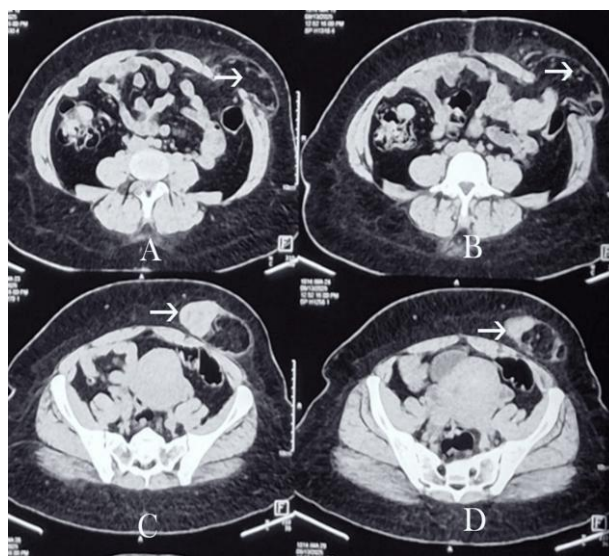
Preoperative computed tomography (CT) imaging.
